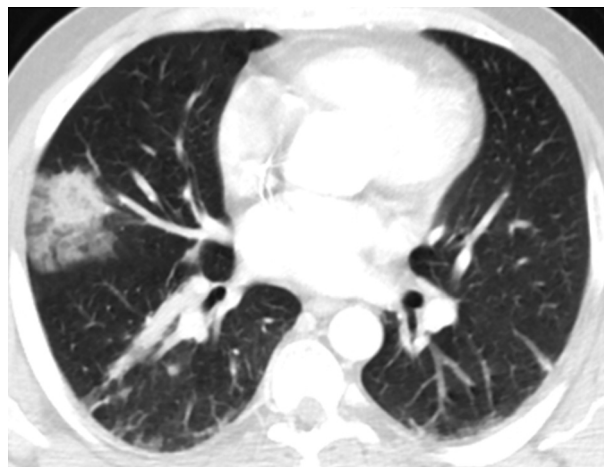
Chest CT revealing the halo sign (a nodular opacity surrounded by a ground-glass halo) in the right lung.
